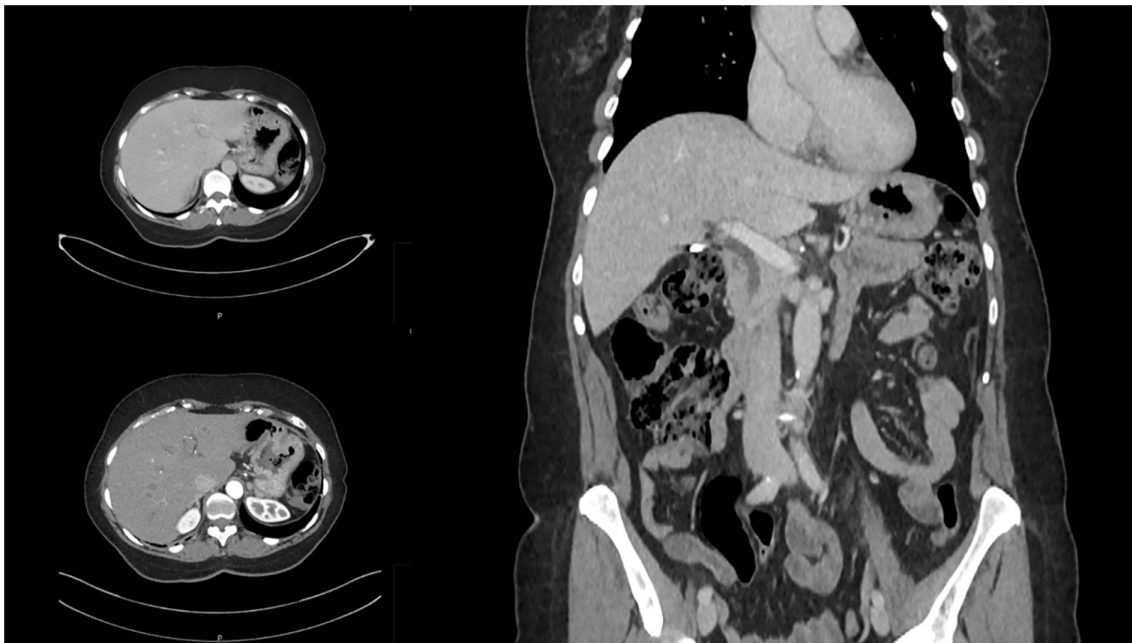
Follow-up contrast-enhanced CT (July 2025) demonstrating no radiologically detectable disease. Left panels: Two representative axial images at different levels of the liver showing no evidence of hepatic metastatic disease. Right panel: Coronal reconstruction confirming absence of recurrent or metastatic disease.
